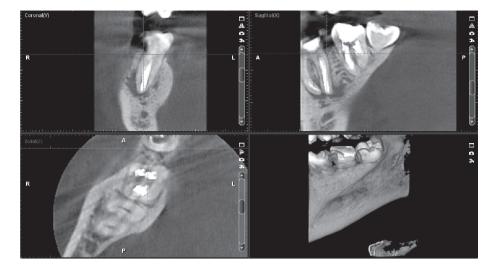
The left lower molars region 3D CT and three-dimensional reconstruction.
